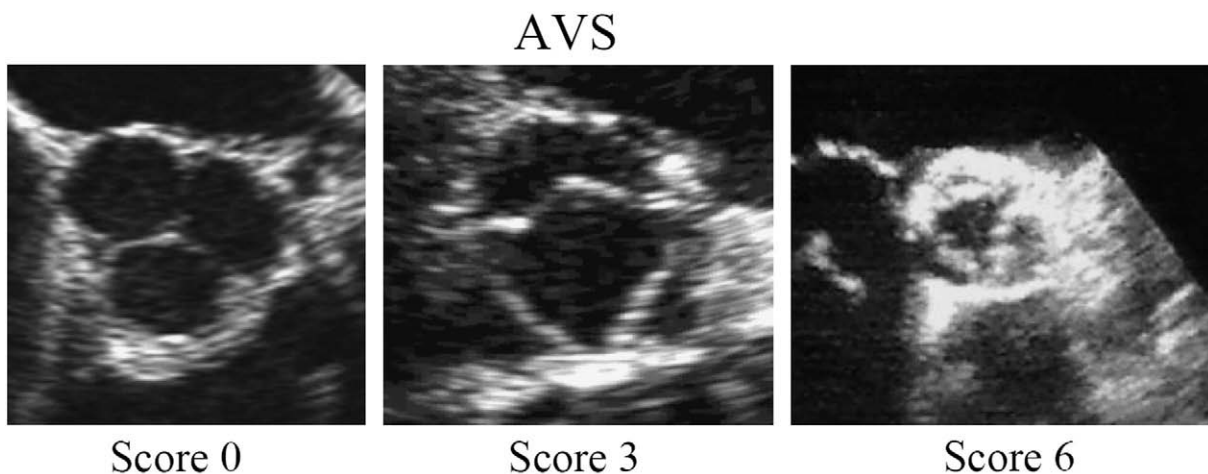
Quantification of AVS — transthoracic parasternal short axis view at the level of the great vessels; score 0 — normal aortic valve; score 3 — enhanced echogenicity of all aortic cusps; score 6 — calcification of all aortic cusps.
